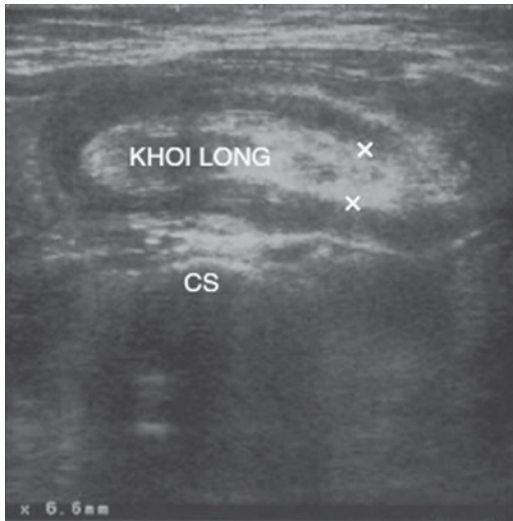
Ultrasonography is the first investigation in infants and children with suspected intussusception. Upper panel shows longitudinal view of intussusception, while lower panel is a transverse section.
